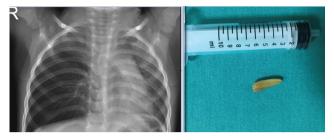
Chest X-ray with non-radiopaque foreign bodies and removed object
